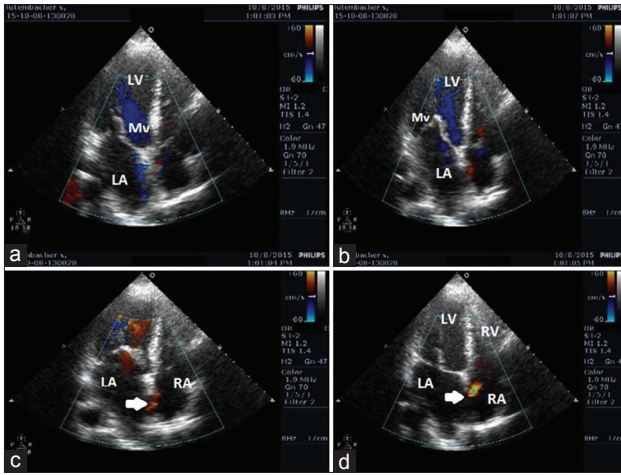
Transthoracic echocardiography apical 4-chamber view image showing thickened, fibrotic, and stenotic mitral valves (a and b), Doppler echocardiography revealed left-to-right shunting across an ostium secundum atrial septal defect (c and d, arrow). RA: Right atrium, LA: Left atrium, RV: Right ventricle, LV: Left ventricle, MV: Mitral valve
